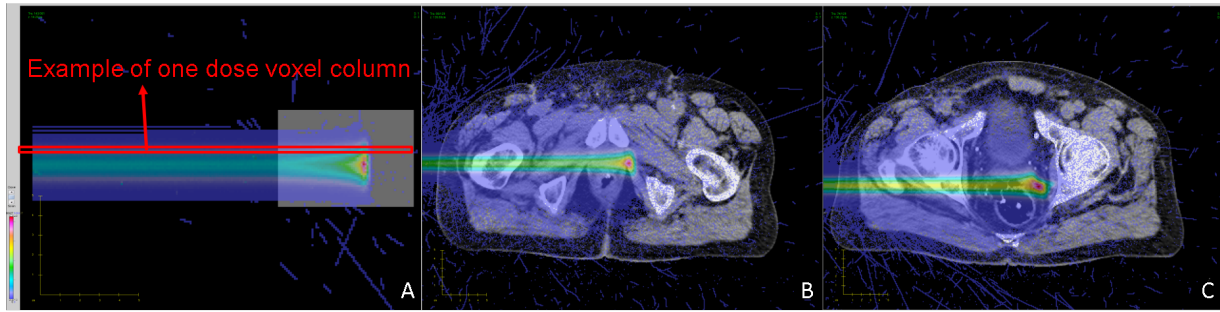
3D MC dose distribution of a given PB passing through (A) water and (B) a relatively homogeneous tissue as well as (C) a pronounced heterogeneous tissue in the pelvic region. The S_{std} calculated values are 0.03, 0.50 and 2.8 mm for A, B and C, respectively. The std values of the CT numbers in the beam path for A, B and C are 0, 199 and 219, respectively. (Tian et al. 2020)
